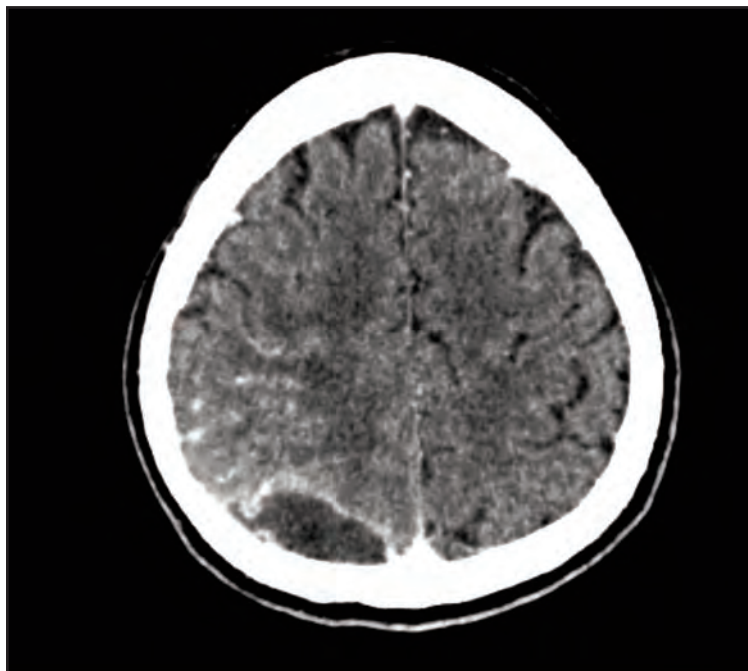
Contrast Computed Tomography of Brain 14 days after treatment
